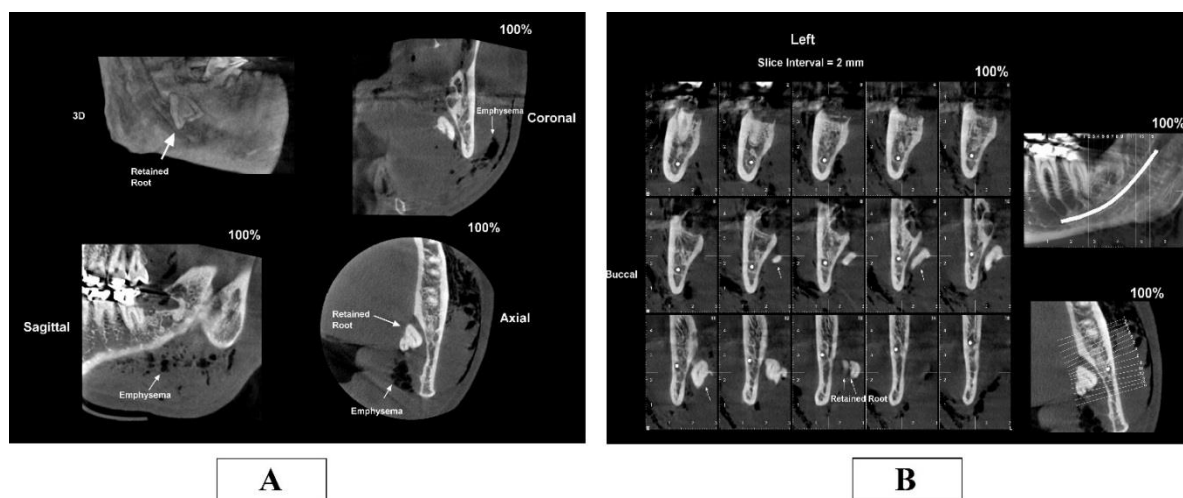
CBCT scans obtained after emphysema developed. A: Coronal, Sagittal, and Axial views of the emphysema and retained root of the wisdom tooth. B: Cross-sectional view of the retained root.
